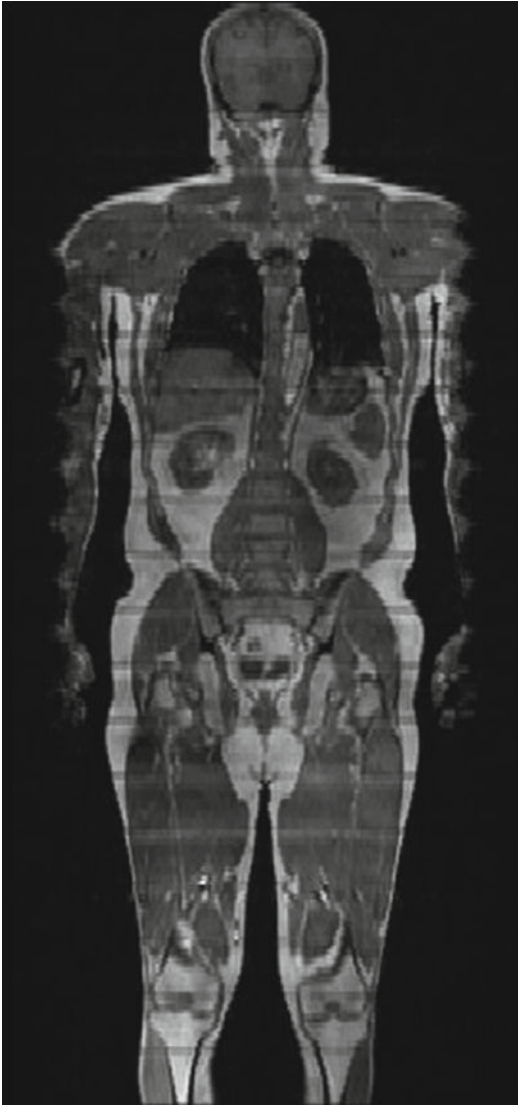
Truncation of extremities frequently shown on MR images (Reprinted from [8] with permission)
